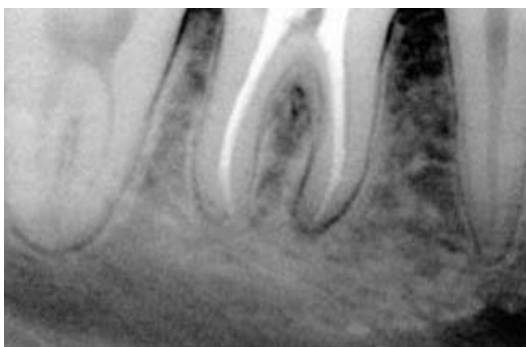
Radiograph of tooth 46 after filling procedure.
